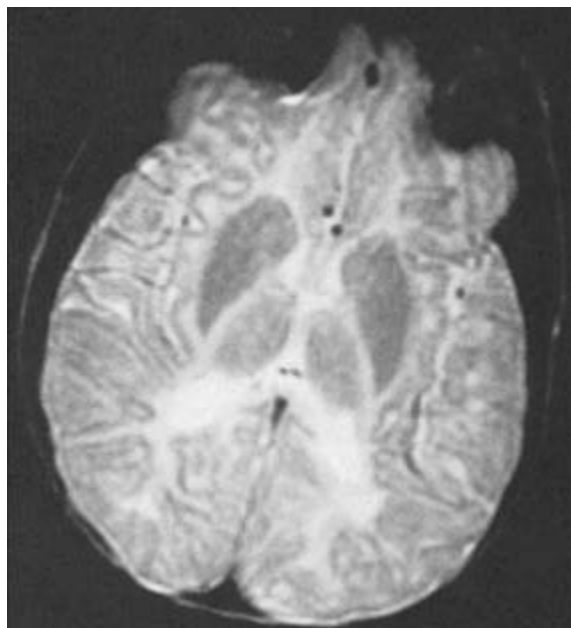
MRI of the brain (SE 200/90) showing paucity of white matter in a 2-year-old boy with Pelizaeus–Merzbacher disease.
